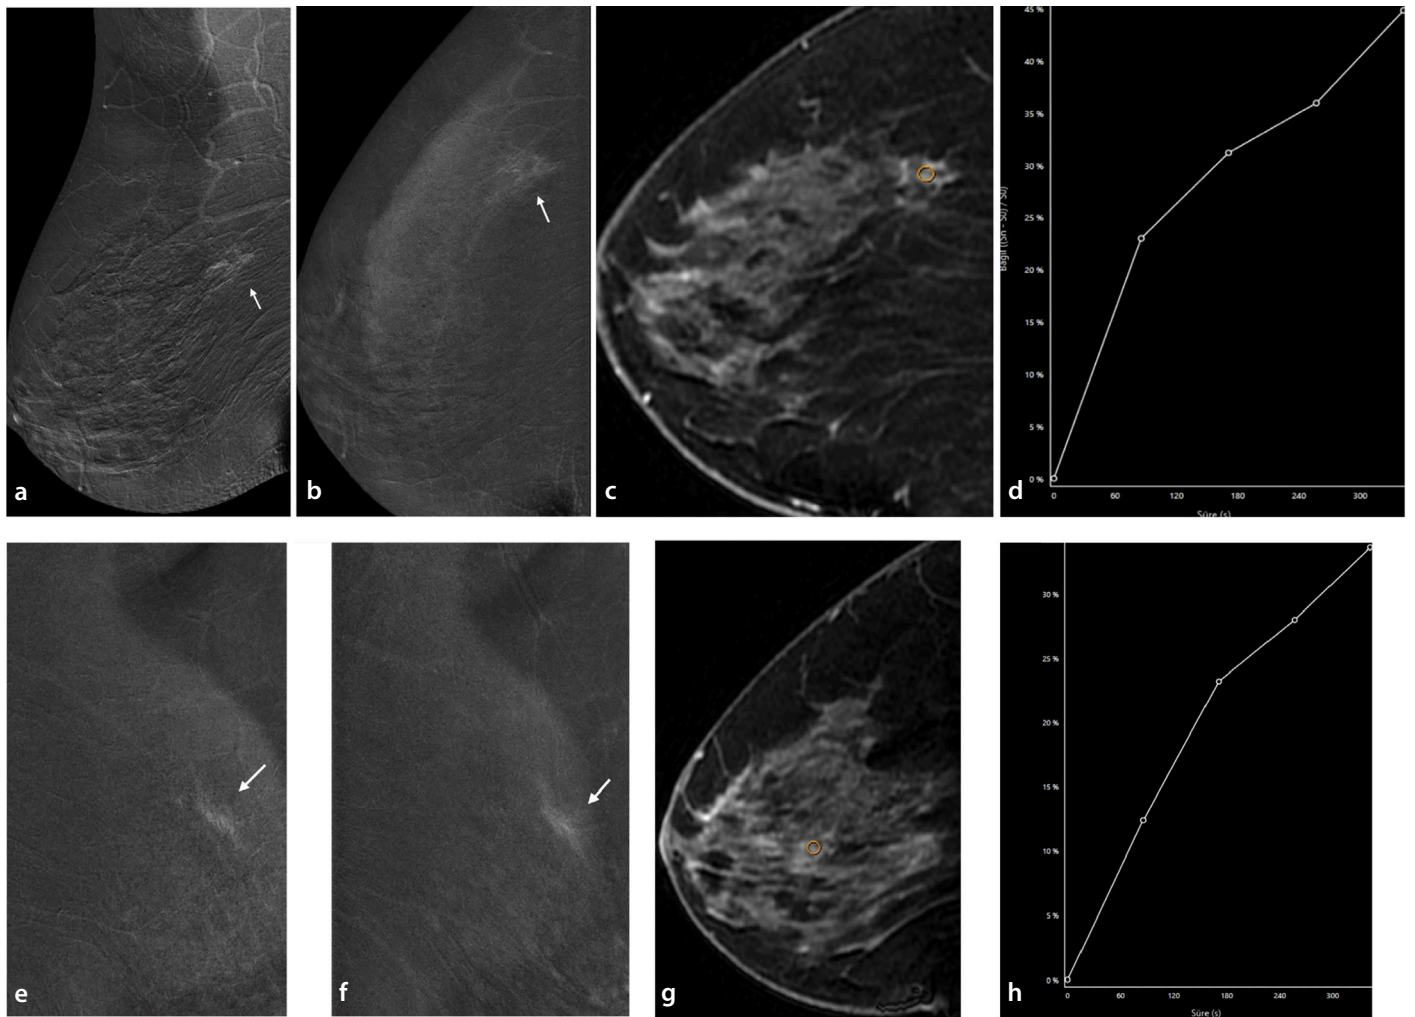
A 62-year-old female patient with non-mass enhancement (NME). On contrast-enhanced mammography (CEM), an ill-defined parenchymal distortion is seen in the right breast at the 2 o'clock position, measuring 2×1.5 cm (a), demonstrating subtle delayed-phase (5th minute) enhancement (b). Corresponding breast magnetic resonance imaging (MRI) shows NME with a type 1 kinetic curve in the same location (c, d). Left breast, CEM reveals additional NME in the retroareolar region and at the 1 o'clock position, approximately 5 cm from the areola (e, f), which are confirmed on MRI with type 1 enhancement kinetics (g, h).
